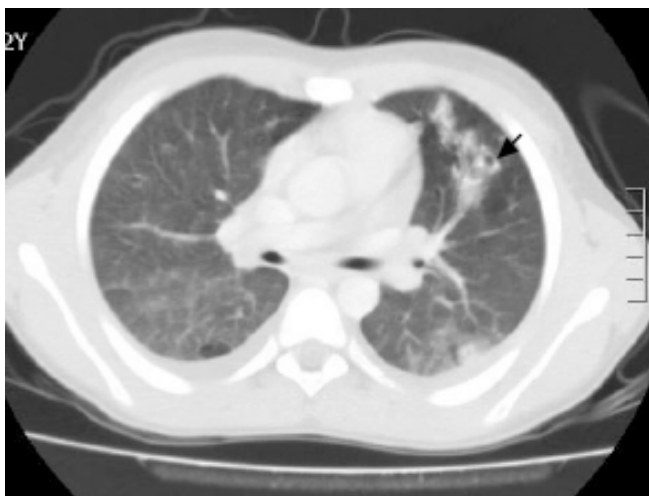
CT scan with cavitating lung nodules (black arrow).
